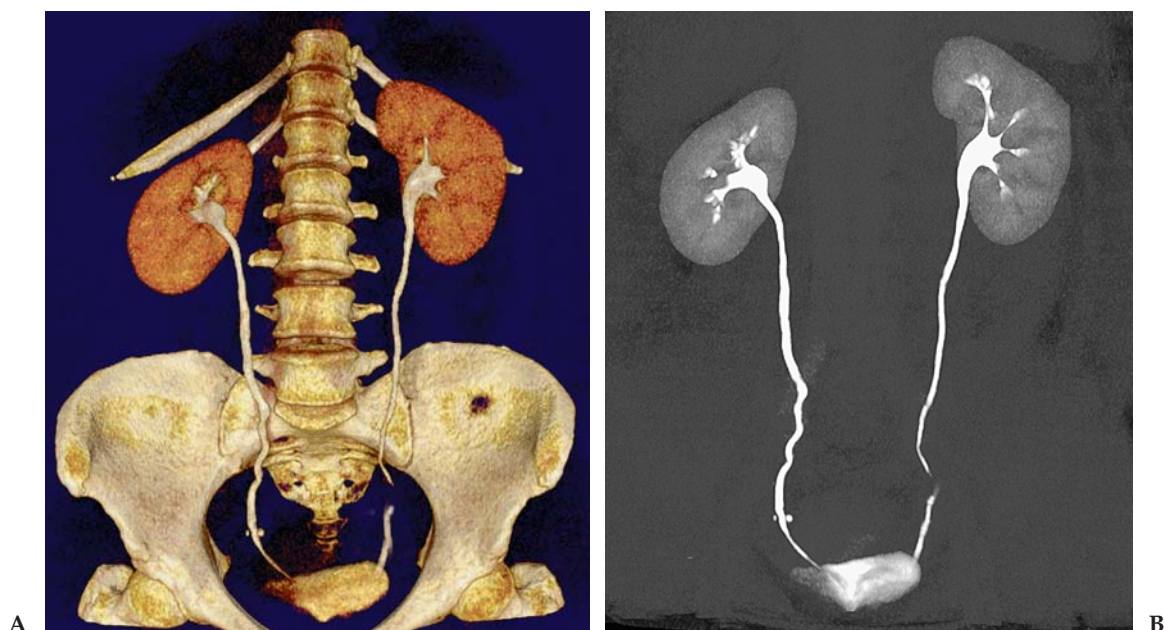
Normal CT urogram. (A) Unsegmented volume-rendered image from a CT urogram. The normal appearance of the collecting systems and ureters is shown. The apparent narrowing in the left ureter is related to peristalsis. The two high-density structures in the right pelvis adjacent to the ureter are phleboliths. (B) Coronal thick-slab MIP image from the same study. The bones have been removed using automated segmentation. Detail of the renal collecting systems is better appreciated on the MIP image.
